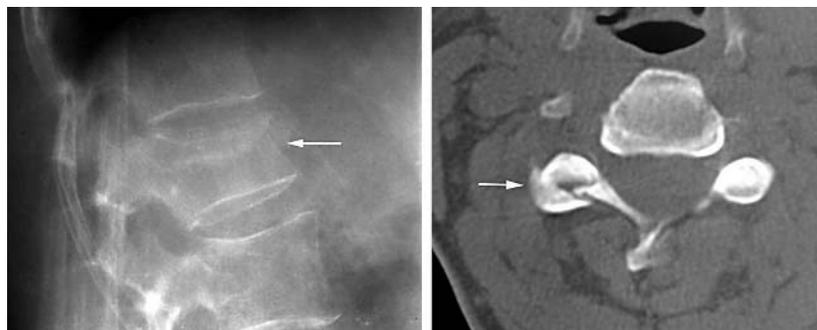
(A) Lateral radiograph of the lumbar spine showing a wedge fracture of the first lumbar vertebra. (B) Axial CT scan of the cervical spine showing a fracture through the right cervical 3-4 facet joint (the fracture through the fourth cervical vertebral body is not seen on this image).
